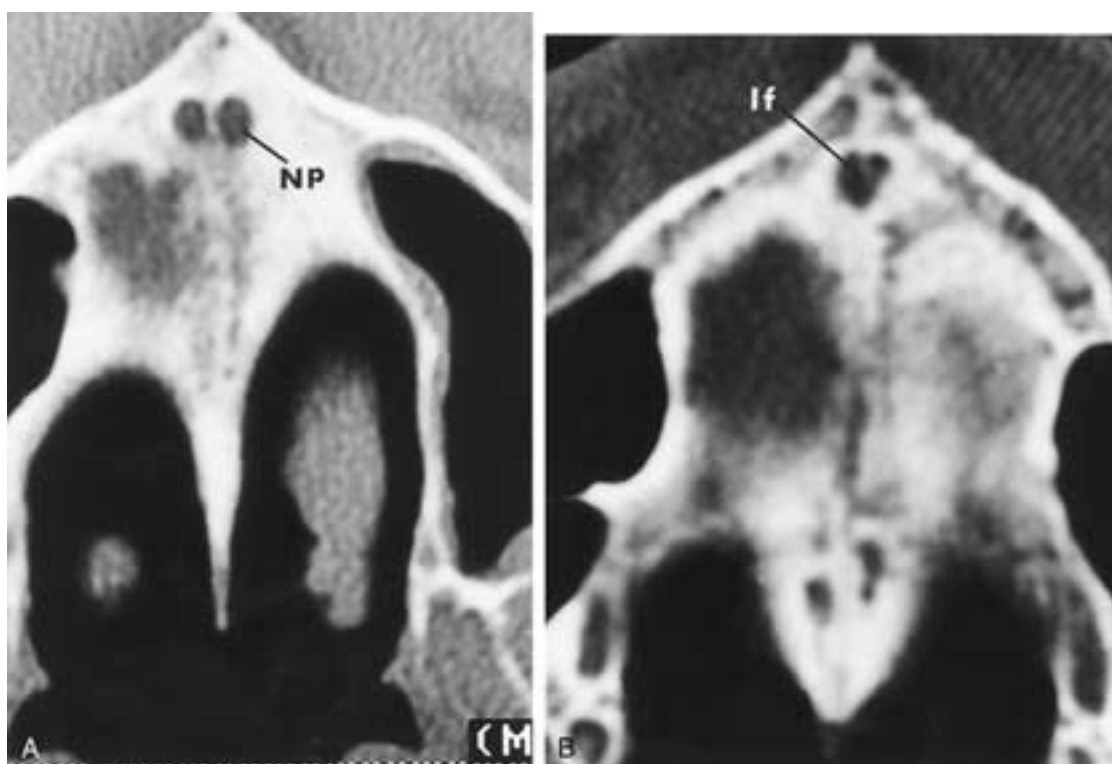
Axial views of the nasopalatine canal and the incisive foramen. A, The more superior axial image demonstrates the two nasopalatine canals (*Np*). B, The inferior slice demonstrates their common opening, the incisive foramen (*If*). (From Abrahams JJ. *Anatomy of the jaw revisited with a dental CT software program: pictorial essay*. AJNR 1993;14:979–990.)
